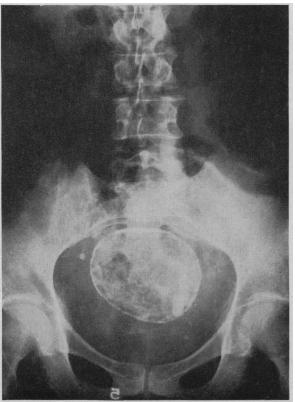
Roentgen appearance of dermoid cyst of the omentum.
